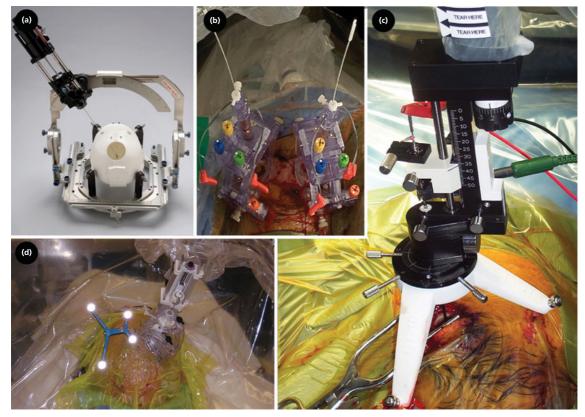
Classic and modern stereotactic devices. Classic frames, such as the CRW (a, Integra), incorporate the fiducials into the stereotactic device using an attached localizer (see Figure 13.1b) during imaging to relate and transform the brain imaging (MRI, CT) space to the physical frame space. The relationship, yielding frame coordinates for adjusting the instrument holder (stereotactic arc, as shown), is calculated using software or by direct measurement on X-ray, CT and/or MRI. Newer stereotactic devices use different approaches. The microTargeting platform (c, Fred Haer Corp.) physically separates the imaging fiducials from the frame. The fiducials are physically attached to the patient's head before CT and MRI imaging and the trajectory is planned on proprietary software. An acrylic stereotactic platform is custom-manufactured (white tripod in \mathbf{c}) that attaches to the fiducials, instantiating in physical space the imaging-planned trajectory (the picture shows the microelectrode drive attached to the platform). The NexFrame (d, Medtronic) also separates the fiducials from the frame. A CT is performed with fiducials attached and co-registered to an MRI for trajectory planning. In the operating room, the relationship of the imaging fiducials to the NexFrame, a plastic stereotactic device affixed atop the burr hole, is calculated by software after detection of their location in physical space using a camera to visualize reflective balls (seen in picture attached to the stereotactic device). The Clearpoint Smartframe (b, MRI Interventions) utilizes a fiducial cannula prefilled with gadolinium. The stereotactic device is affixed to the patient in the MRI scanner, and the relationship of the cannula (physical space) to the brain space is determined with an MRI. The software calculates the necessary adjustments to align the attached tower containing the fiducial cannula to the planned trajectory, which are made using four coloured knobs. The DBS is inserted through the fiducial cannula, as shown.
